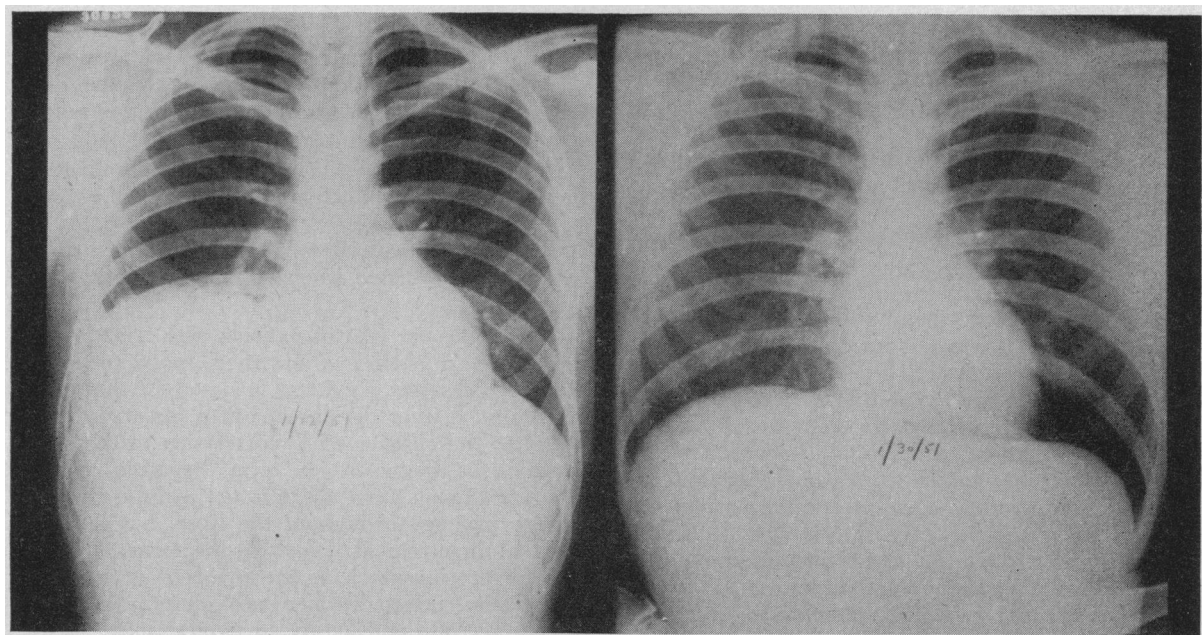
Left*—Chest roentgenogram taken before treatment. *Right*—18 days later: return of right diaphragm to normal position with clearing of the neighborhood reaction at the right lung base.
